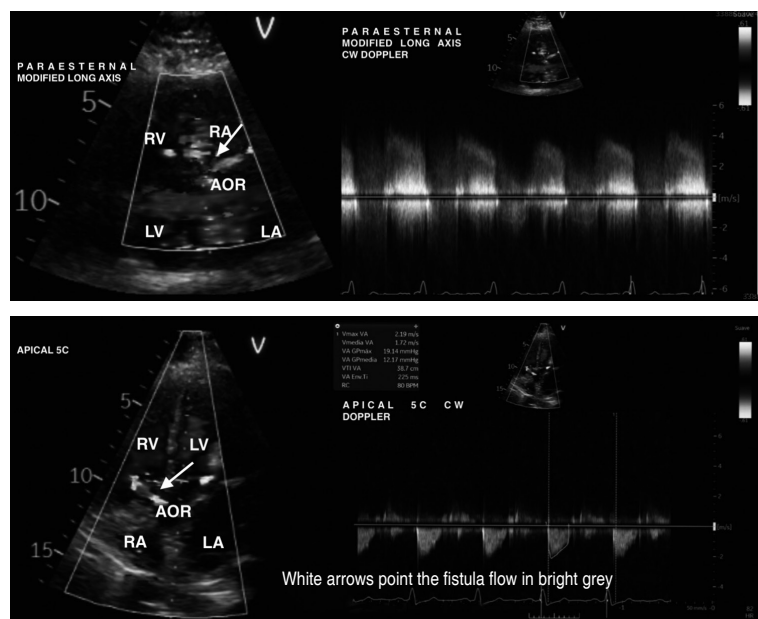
Transthoracic echocardiogram. Upper images in the parasternal long axis, lower images in the four-chamber apical axis showing a fistulized right coronary aneurysm (white arrows), with high-speed flow in the subaortic region, which is directed towards the right cavities.
